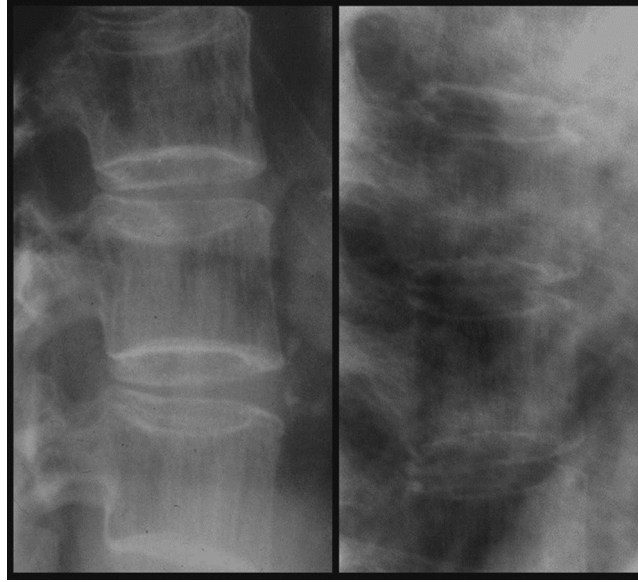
(Left) Increased vertical striation due to the proportionally greater loss of horizontal trabeculae and compensatory hypertrophy of the vertical trabeculae. (Right) Severe osteoporosis: the vertebrae can hardly be distinguished on the lateral lumbar spine radiograph. There are multiple end-plate and compression fractures.
